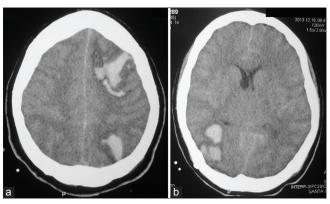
Computed tomography. (a) Image showing frontal and parietal left hemisphere hemorrhage. (b) Image showing occipital right hemisphere hemorrhage
